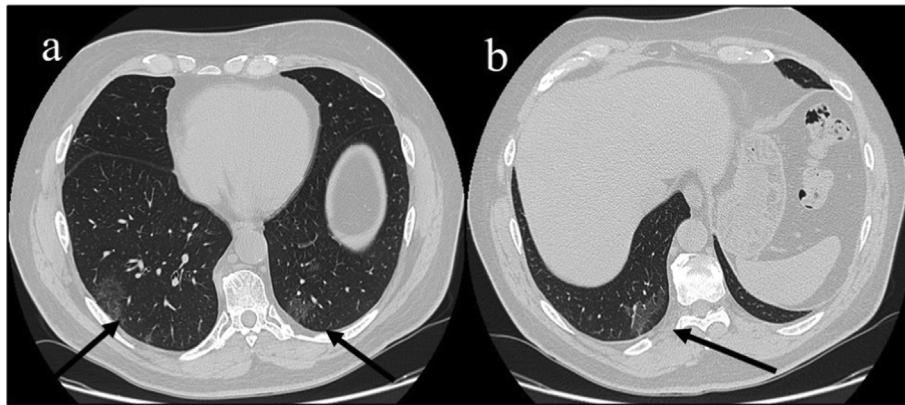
Images a,b represent GGOs (black arrows) in a typical radiological pattern with peripheral and posterior distributions in the inferior lobes on the chest CT scan of the first patient.
